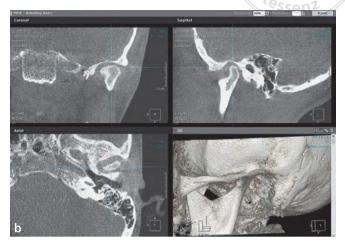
and b CBCT of the TMJs (Picasso, Orange Dental)²⁰. a) Right side showing retruded codylar position. b) Left side also with retruded condylar position but more dislocation. No cortical bone pathology on either side.
